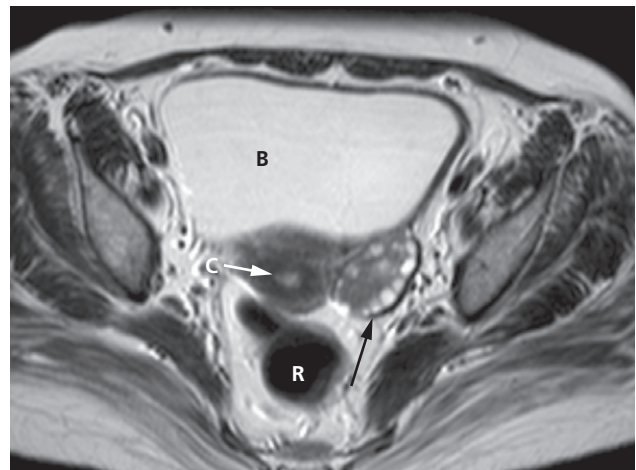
Polycystic ovary. Axial T2-weighted MRI demonstrating a left ovary (black arrow) which is large in size and has multiple small cysts arranged around the periphery of the ovary, in a characteristic 'string of pearls' distribution. B, bladder; C, cervix; R, rectum.
